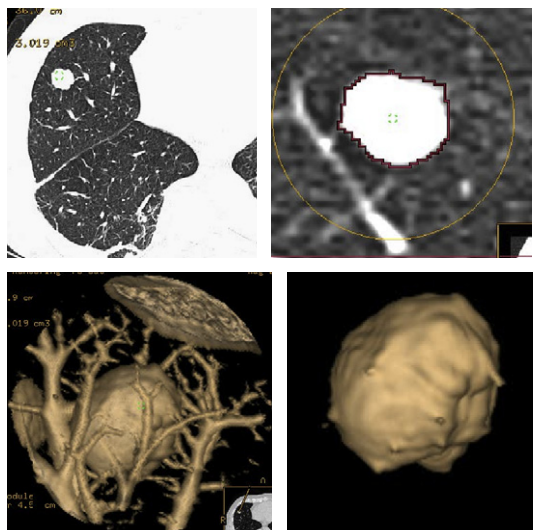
Advanced lung analysis lesion sizing from 3D CT.
